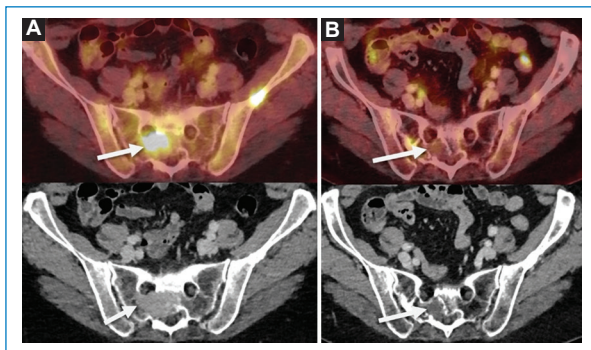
FDG PET/CT fusion and axial CT of venous pelvis for multiple myeloma staging (A) showing a sacral hypermetabolic osteolytic lesion with soft tissue density (arrows) and a non-displaced left iliac fracture. In the post-treatment control (B), a complete response is observed, characterized by resolution of metabolism, decreased impregnation with contrast, and appearance of sclerotic margins (arrows).
